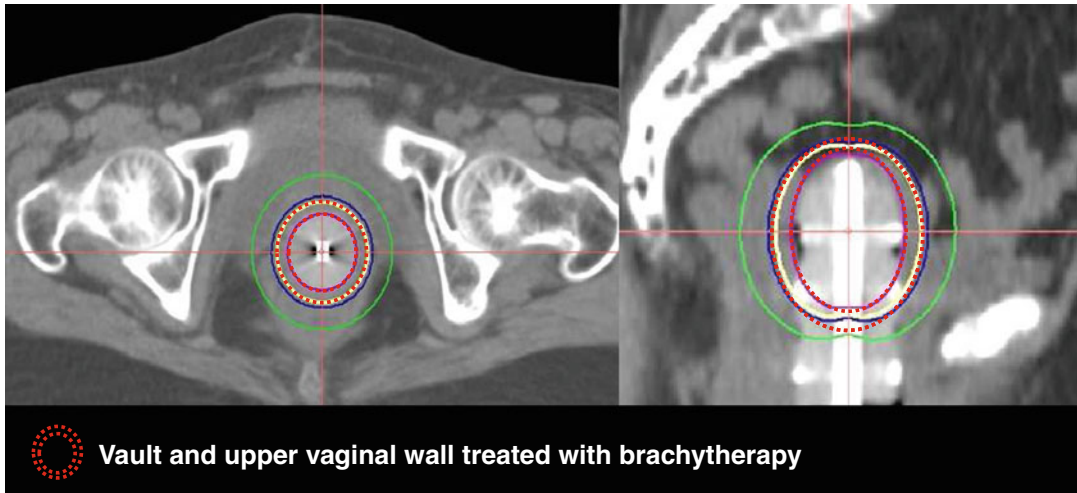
Axial and sagittal CT images showing intravaginal brachytherapy cylinders, brachytherapy doses to vault, and upper vaginal wall
